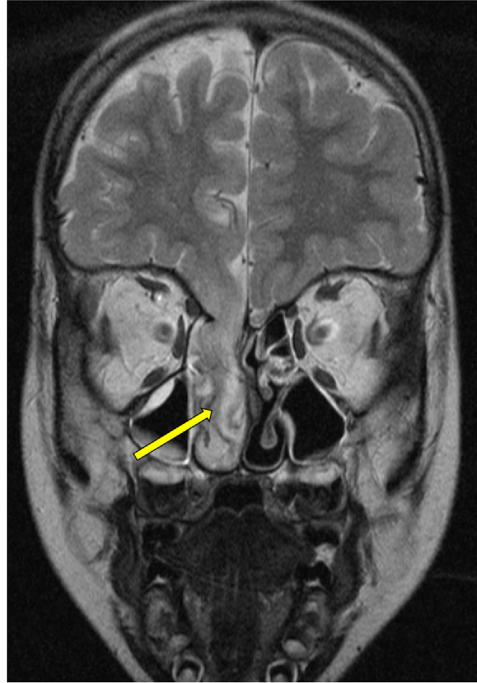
MRI scan demonstrating an ethmoidal encephalocele.
